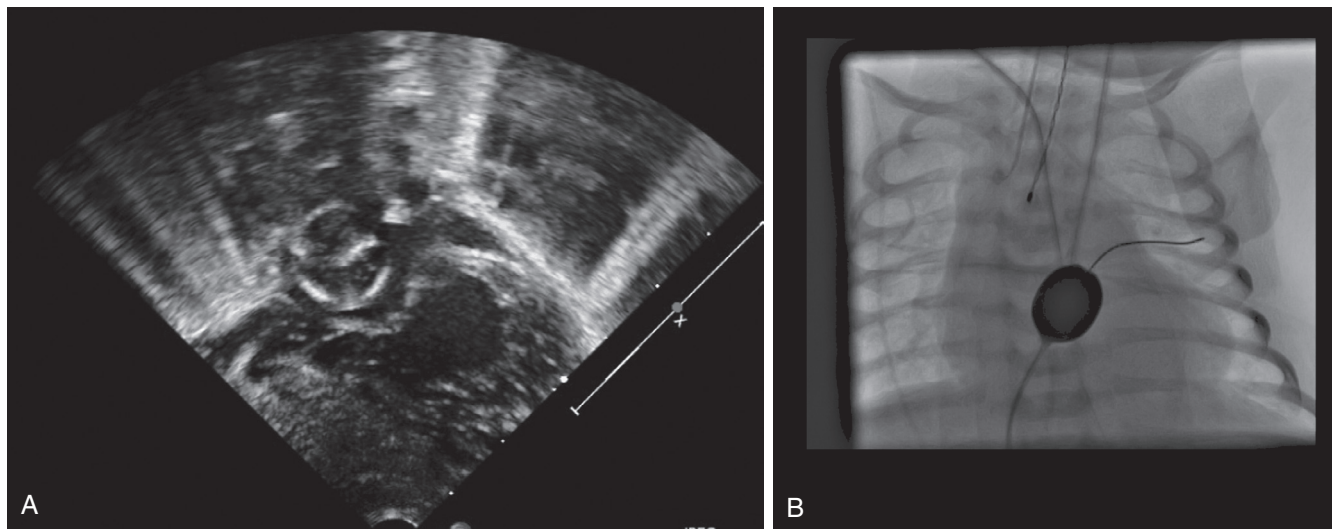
■ The mode of imaging during balloon atrial septostomy depends largely on the location of the procedure. A, Echocardiographic image of the saline-filled septostomy balloon in the left atrium. B, Fluoroscopic visualization of the contrast-filled septostomy balloon in the left atrium over a wire course into a left pulmonary vein.
